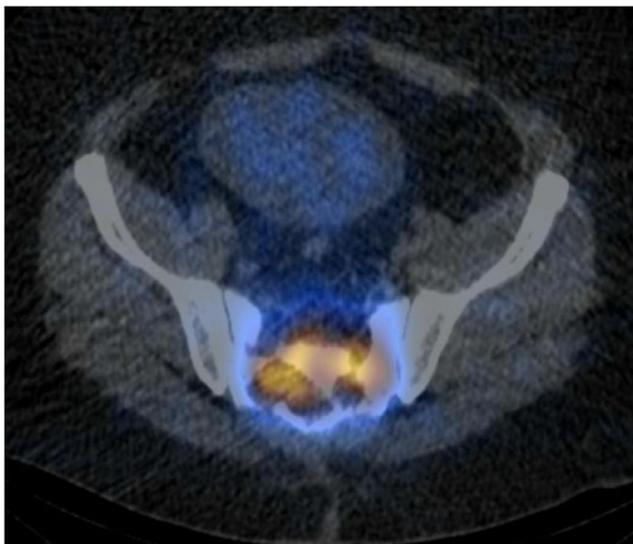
I-123 metaiodobenzylguanidine (MIBG) scan SPECT/CT demonstrated increased I-123 MIBG activity within the sacral lesion. No other foci of abnormal uptake were seen elsewhere
